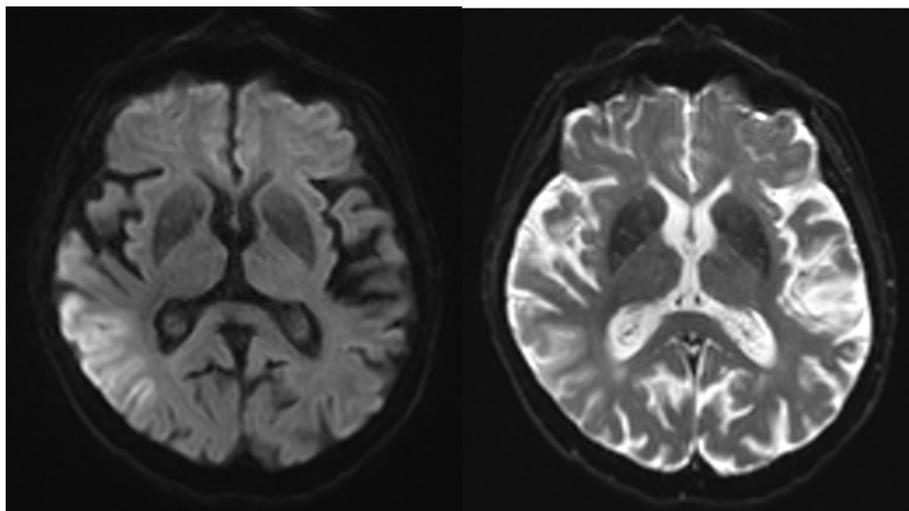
Typical right SLL with occipito-temporal distribution in a female with MELAS showing up as hyperintensity on DWI and hyperintensity on ADC.
